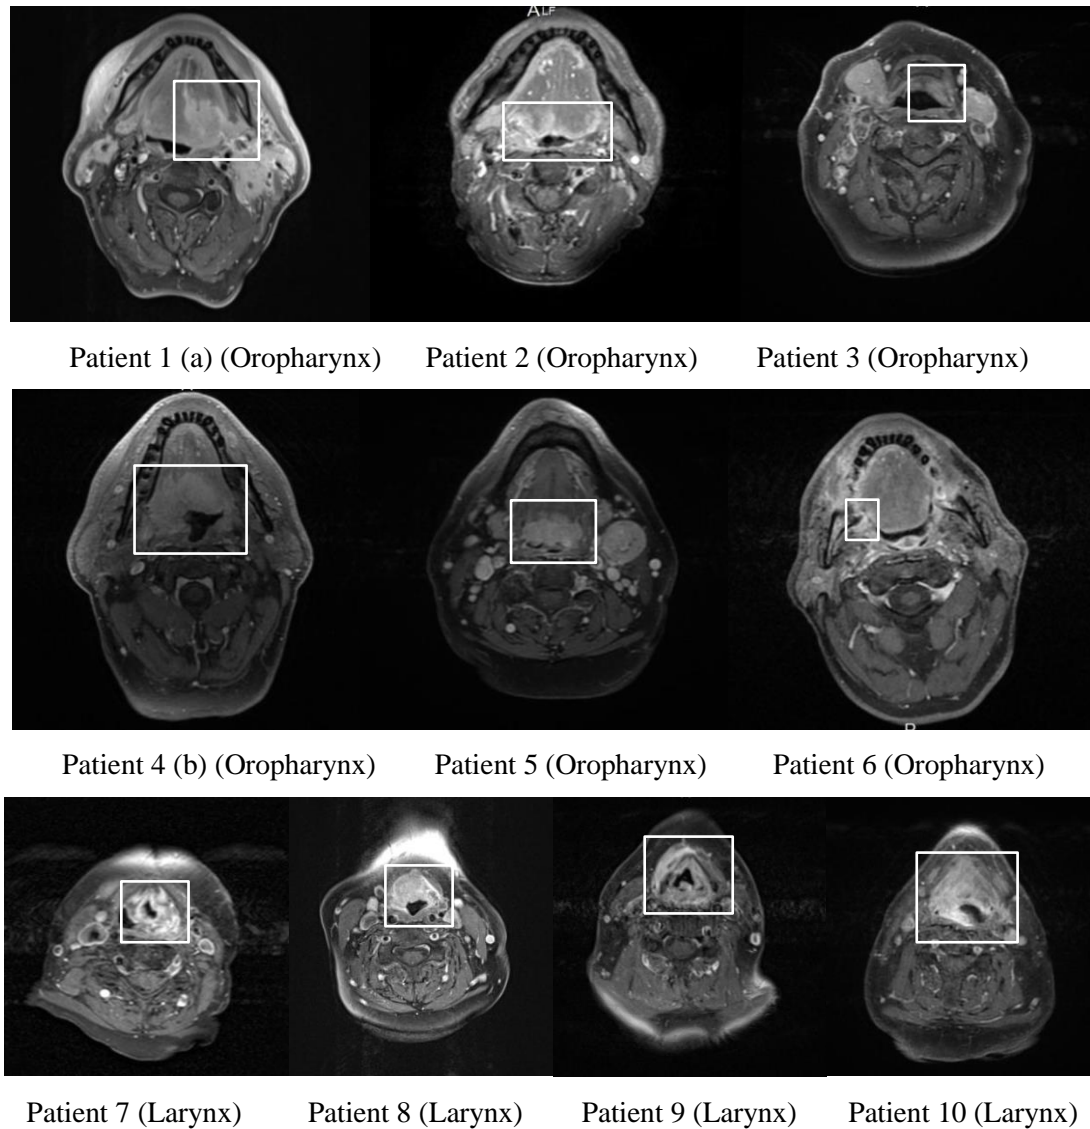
Typical real T1+Gd MRI slices, obtained from different MRI scanners with different imaging protocols, with oropharynx and larynx tumours present (white outline), from each of 10 patients used in this research. Different contrast uptake, shape and size, intensity overlap with neighbouring structures of the tumour regions (GTV) can be observed (a) MRI slice with tumour that is not fully enhanced. (b) MRI slice with tumour diffused in normal tissues with no distinct edge.
